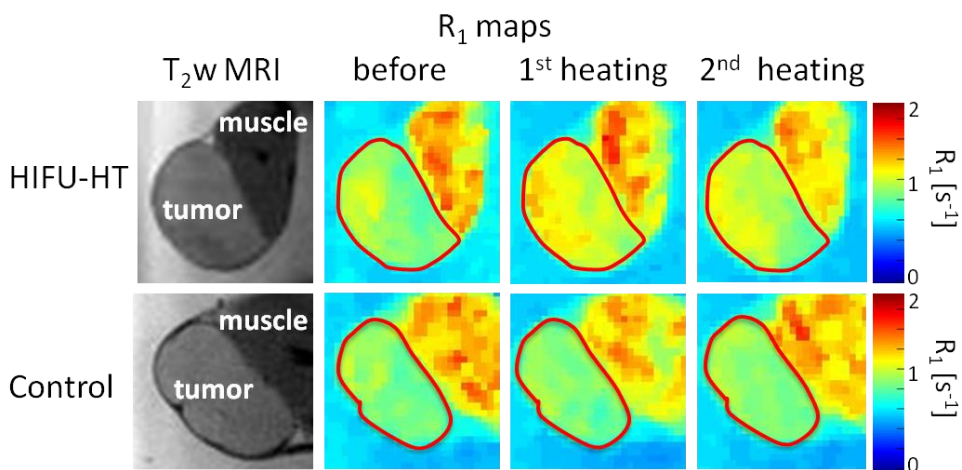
T₂-weighted MR image and R₁ maps before TSL injection and after each heating period, with HIFU-mediated hyperthermia (upper row) and control (lower row). On the R₁ maps, the tumor is delineated with a red line.*
